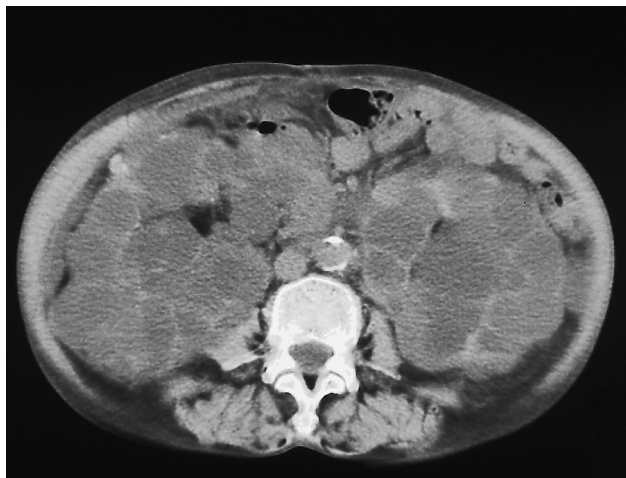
A CT scan before TAE shows grossly enlarged polycystic kidneys.
